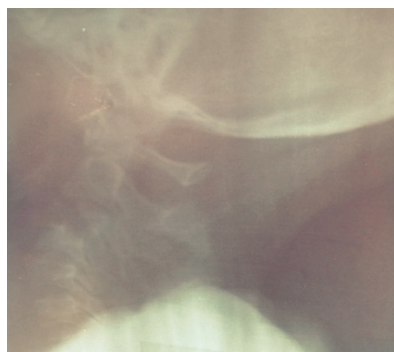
X-ray of the cervical spine in profile view showing an image of significant osteolysis of the vertebral bodies of C3 and C4.
